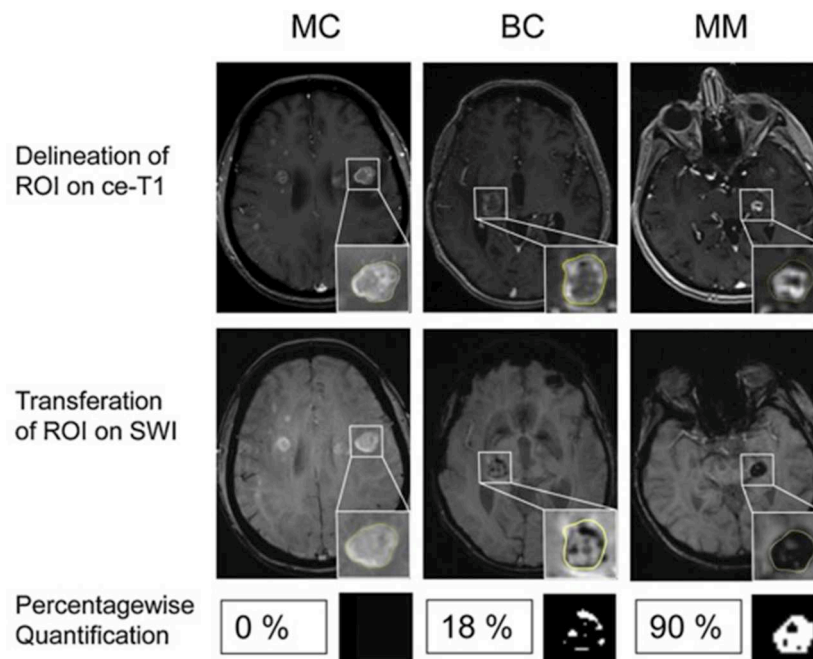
Differentiation of brain metastases by ITSS. Examples of patients with MC, BC and MM. (Upper) Contrast enhanced T1-weighted images (ce-T1). (Middle) Contrast enhanced susceptibility weighted images (SWI). Insets: Delineation of the enhancing lesion on ce-T1 images and corresponding ROI on SWI. (Lower) Percentagewise ITSS quantification with corresponding binarized ITSS map. No ITSS (0%) in MC, minor ITSS (18%) in BC and subtotal ITSS (90%) in MM. Adapted from Radbruch et al. (48).
